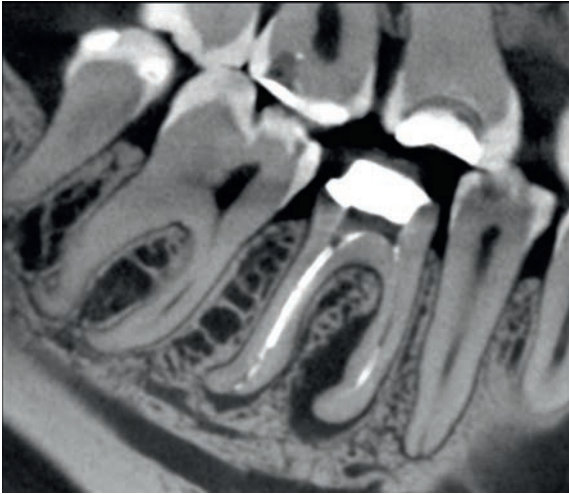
CBCT sagittal image.
